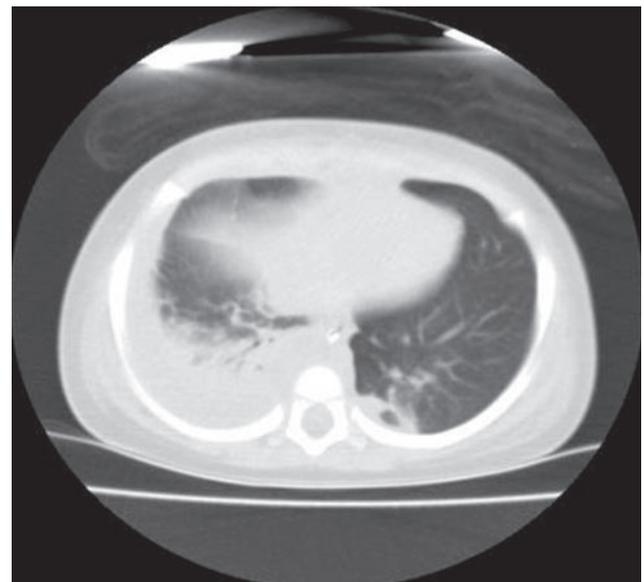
CT of the chest showing an area of consolidation with an associated moderate sized pleural effusion in the right hemithorax.
